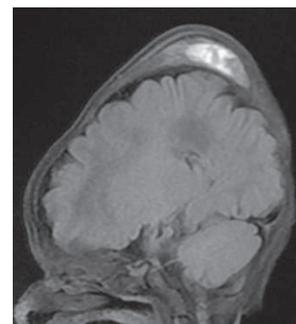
(B): Sagittal FLAIR Image
